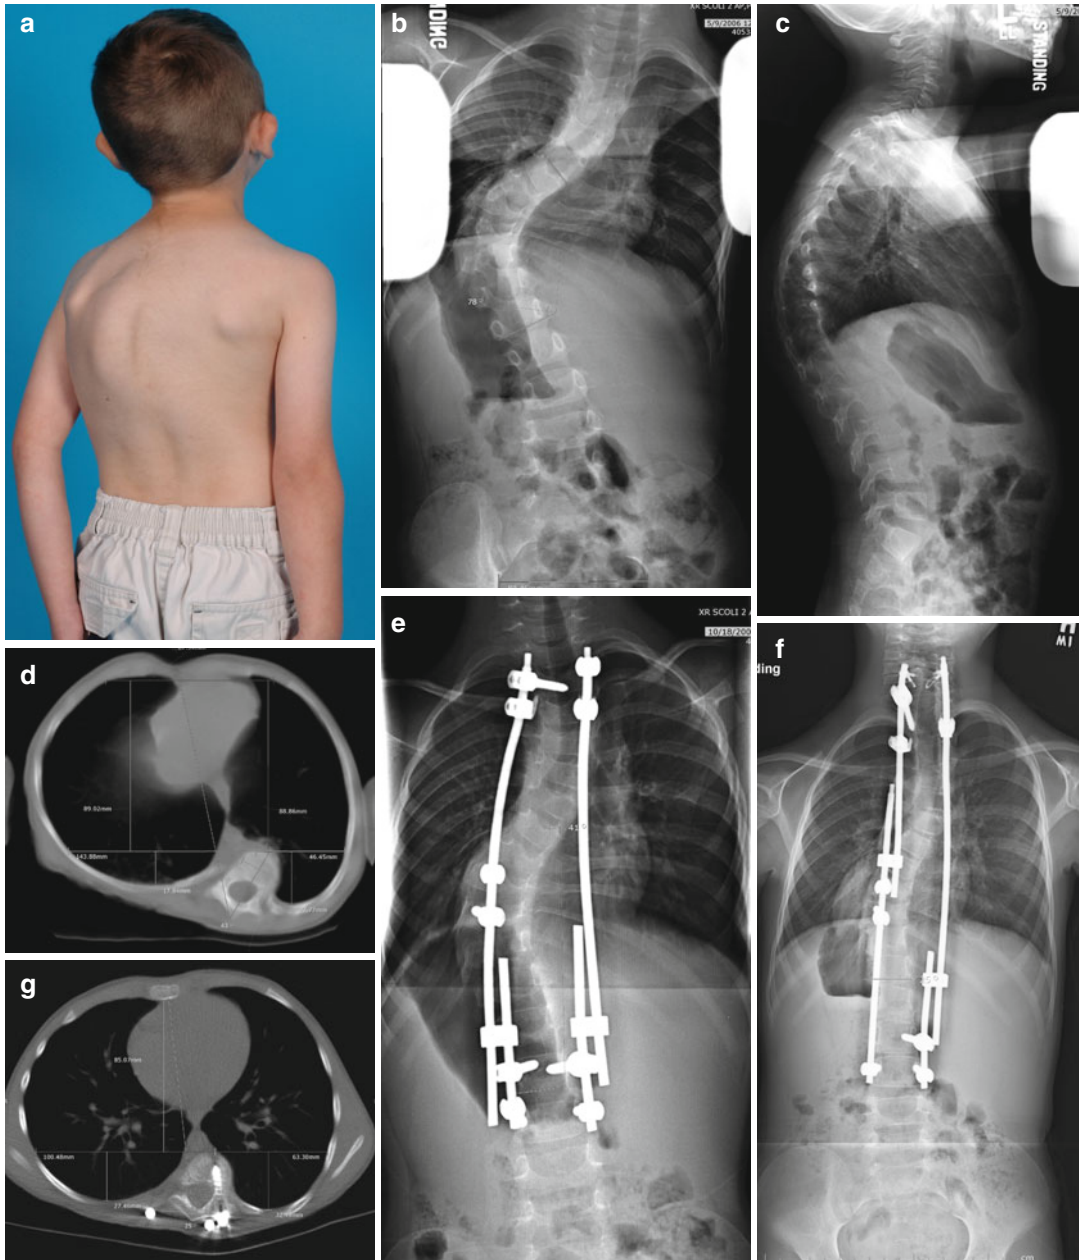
(a) Clinical appearance at age 6 years. (b) A 78° scoliosis with a short 14.5 cm T1–12 length, significantly <3rd percentile. (c) Lateral radiograph at age 6 years. The patient underwent preliminary traction due to the kyphosis. (d) Axial CT of chest showing spine penetration into the convex hemithorax. Convex to concave ratio [10] $46.5/143.9 = .32$ (normal = 1). Concave anterior-to-posterior ratio [10] $89/17.7 = 5$ (normal at T10 = 2.5). Axial rotation = 43°. (e) Immediate postoperative radiograph following GRI with apical control. Scoliosis
